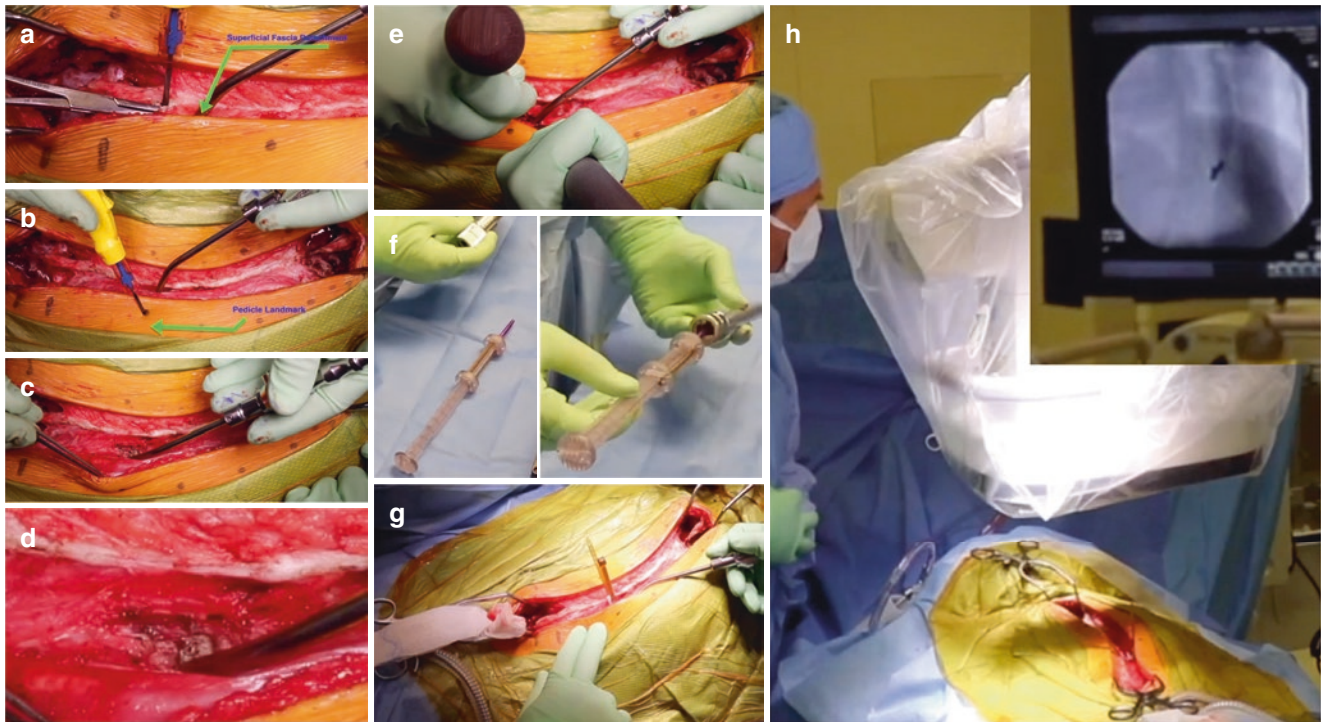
(a) The erector spinae are split with the multifidus and spinalis spinous process left medially with the longissimus and iliocostalis reflected lateral. Transverse process is visualized. (b) Pedicle is identified using the skin marking obtained using preoperative radiographs. (c) The pedicle location is located via a transmuscular approach. (d) A
